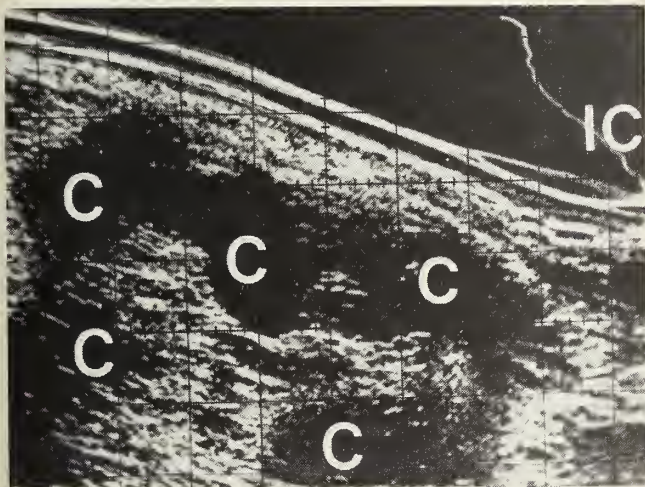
Polycystic Kidney. High gain longitudinal renal ultrasonogram demonstrating multiple echofree foci (Cs) within an enlarged kidney. Iliac crest (IC).
